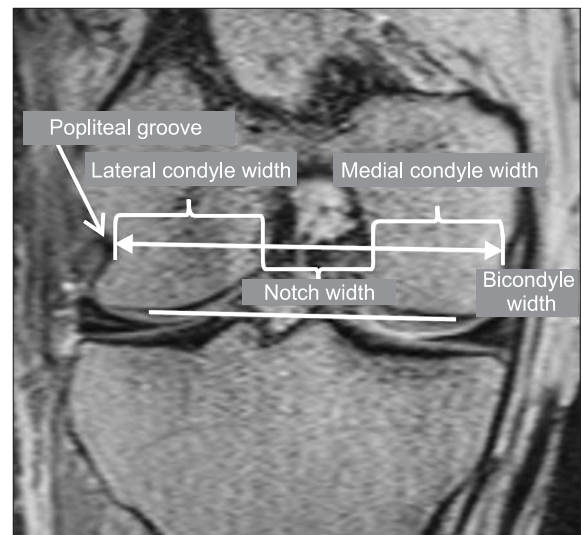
T1 coronal view of knee magnetic resonance imaging. A line is shown along the most inferior part of the femoral condyles and a line parallel to this line at an intermediate imaging among the obtained ones where the popliteal grooves are seen, where the indicated morphometric values were measured.
